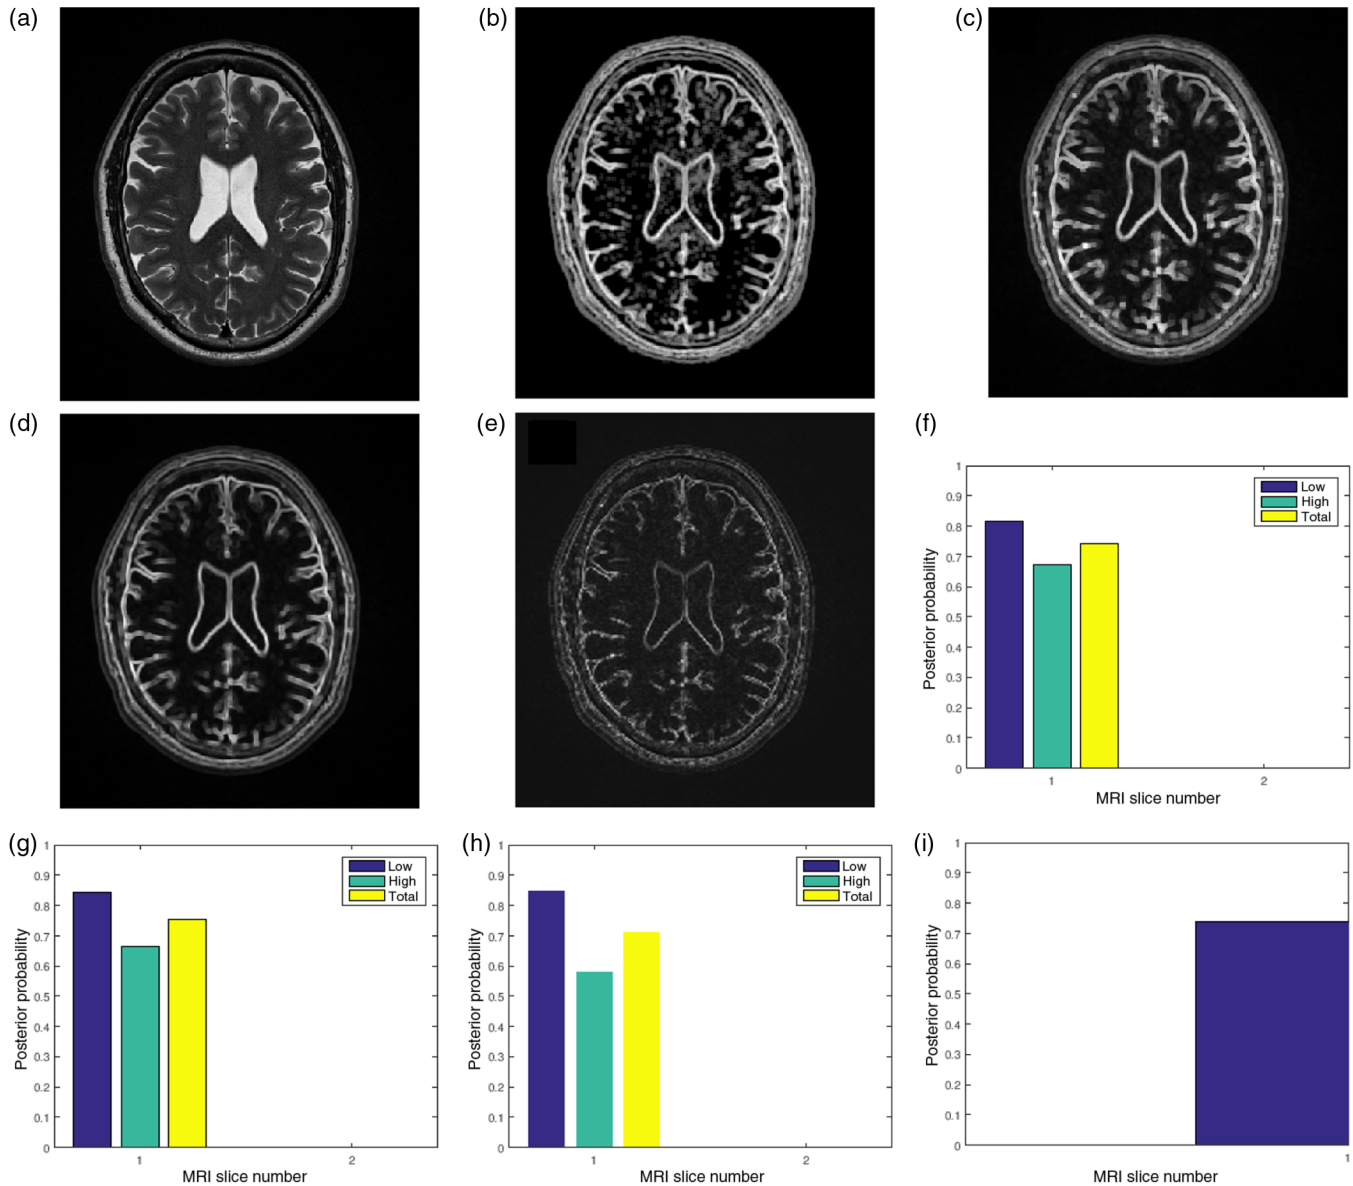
Bayesian framework inspired postacquisition quality assessment of (a) a brain MRI slice (TIM) in an MRI volume data. The event of interest, (b) the local entropy (ENT) is extracted from the test image. Three separate observations of image quality are (c) local contrast (CON), (d) local standard deviation (STD), (e) and local sharpness (DTL) feature images. The four feature images are transformed to the binary domain and classified into the low- and the high-energy regions. For each region, the posterior probability of each region given any of the observations gives quality score for (f) contrast quality attribute, (g) standard deviation quality attribute, and (h) sharpness quality attribute. The total quality score for each region is the average quality scores from each quality attribute. The average total quality score from each region is the (i) global quality score.
